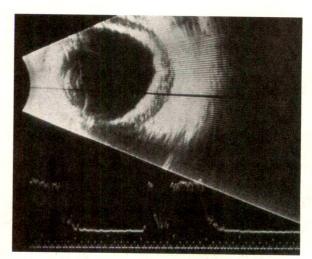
(Ward and associates). Ultrasonography demonstrating thickened retinochoroidal layers with choroidal elevation.
